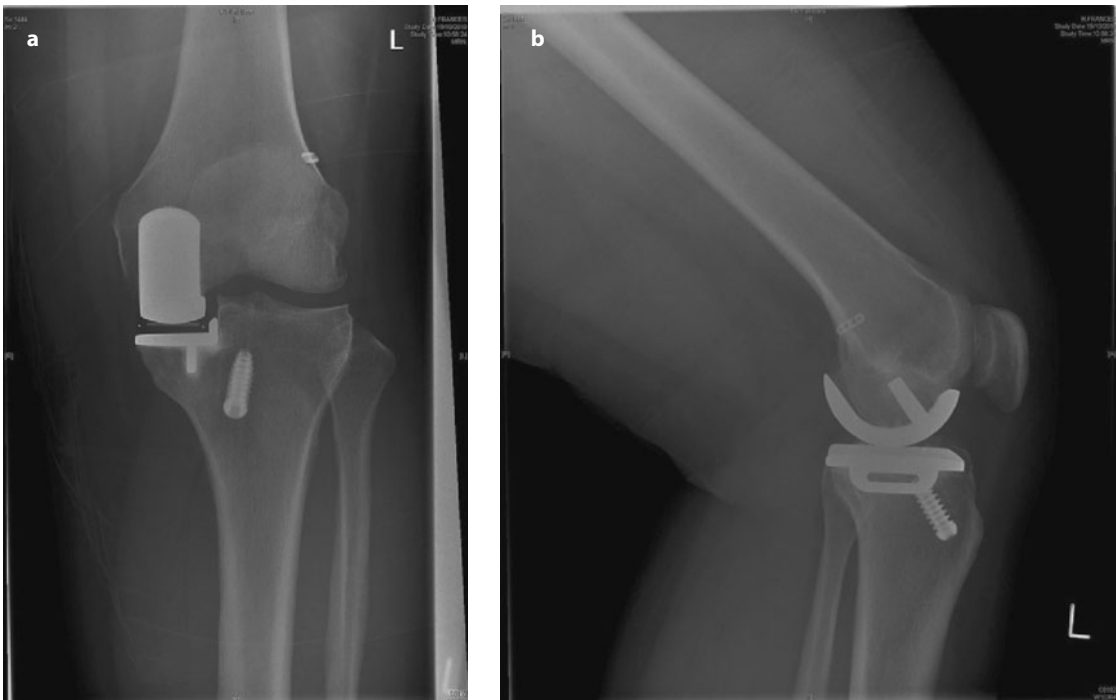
Radiographs of an Oxford UKR combined with ACL reconstruction; antero-posterior (a) and lateral (b) views (with thanks to Dr. Dodd, of Oxford)
